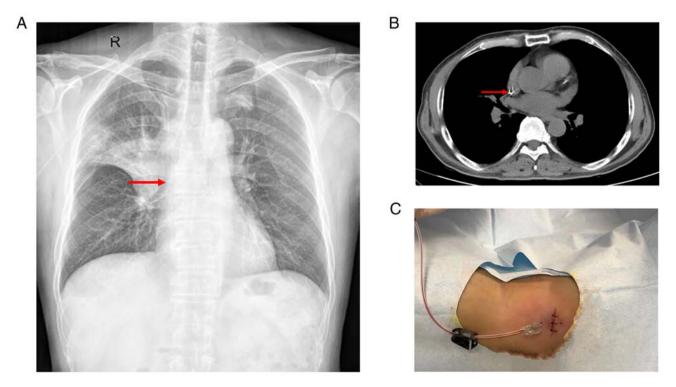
(A) Representative post-procedure chest X-ray, (B) corresponding chest CT image and (C) photograph of insertion site. The red arrow in A and B indicates the catheter tip.
